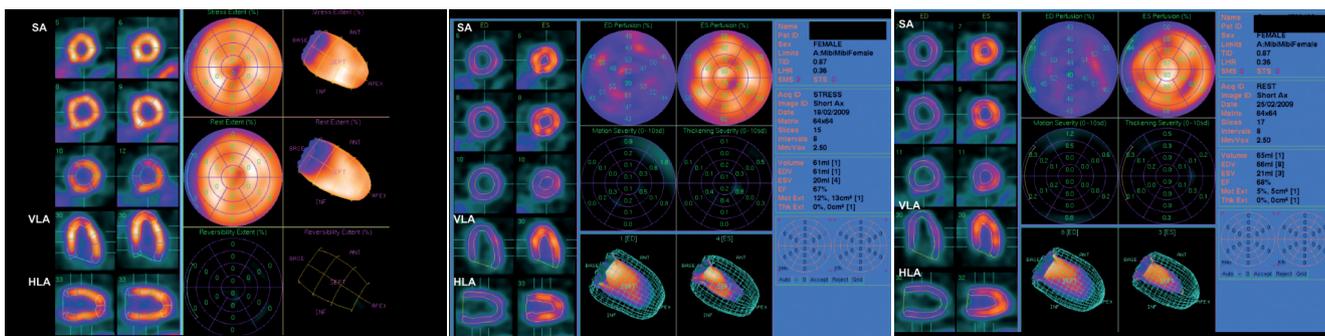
Example of a normal dobutamine stress gated $^{99\text{m}}\text{Tc}$ -sestamibi SPECT study for assessment of myocardial perfusion and function. A. Dobutamine stress gated $^{99\text{m}}\text{Tc}$ -sestamibi SPECT in an obese female patient with a body mass index 42, and a history of coronary intervention, hypertension and diabetes. Left column, from top to bottom: short-axis (SA), vertical long-axis (VLA) and horizontal long-axis (HLA) slices. All slices show normal perfusion without defect. Middle and right column: polar maps and 3-dimensional projection of the perfusion scan demonstrating a normal perfusion at stress and rest. B. Continued: quantitative analysis of the dobutamine stress SPECT images. Left column: end-diastolic (ED) and end-systolic (ES) slices. Middle column from top to bottom: ED and ES polar plots, quantitative analysis demonstrating normal wall motion and wall thickening, left ventricular ejection fraction (LVEF) is 67%. C. Continued: quantitative analysis of the resting SPECT images. Quantitative analysis demonstrating normal wall motion and wall thickening, LVEF is 68%.
